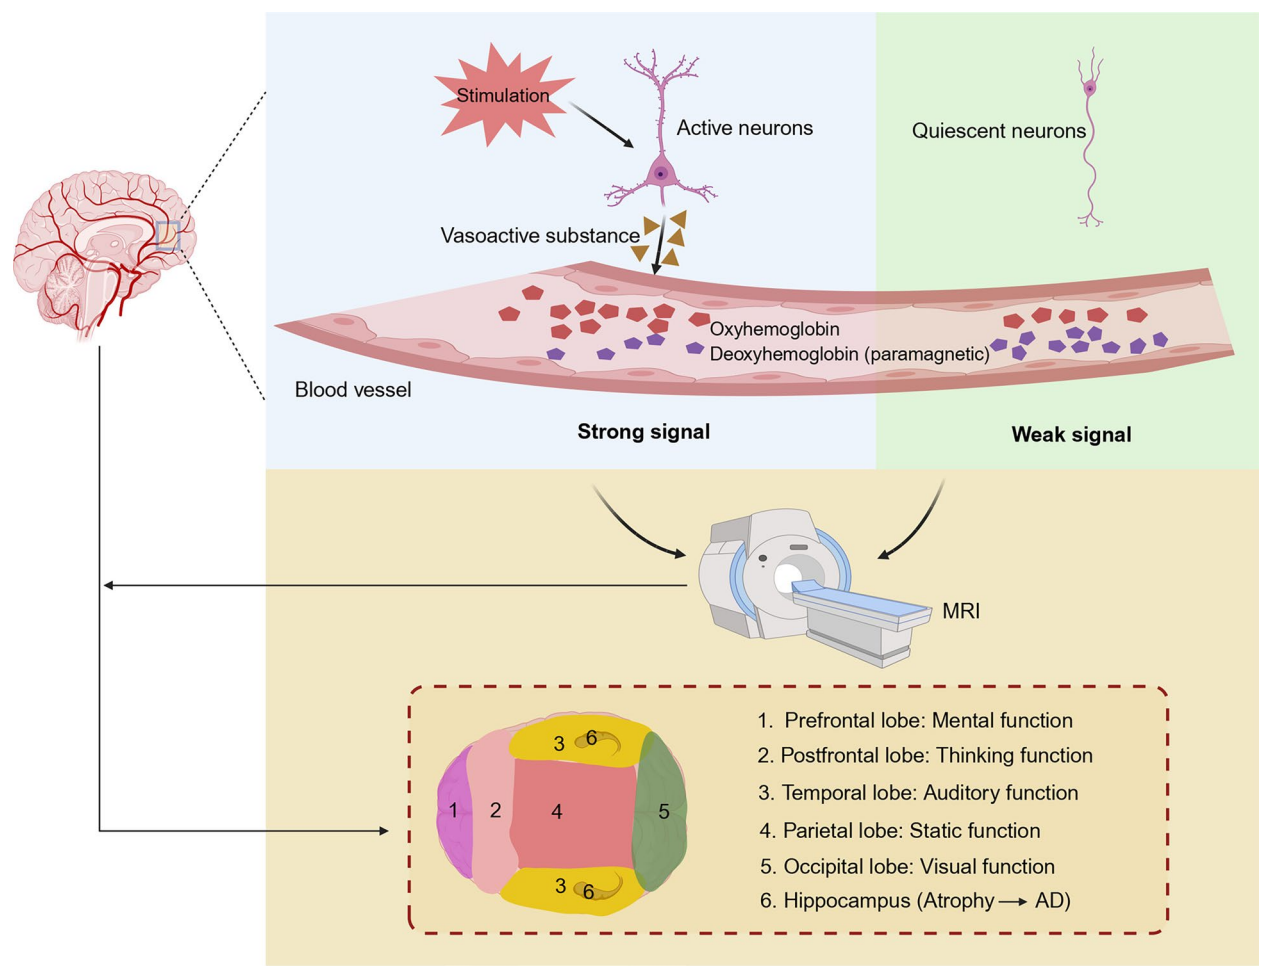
MRI imaging principles
